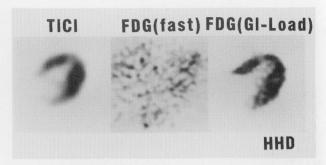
F-18-FDG fasting images in a 47-year-old female with HHD reveal little uptake, while the glucose-loading images reveal normal uptake in the myocardium.
